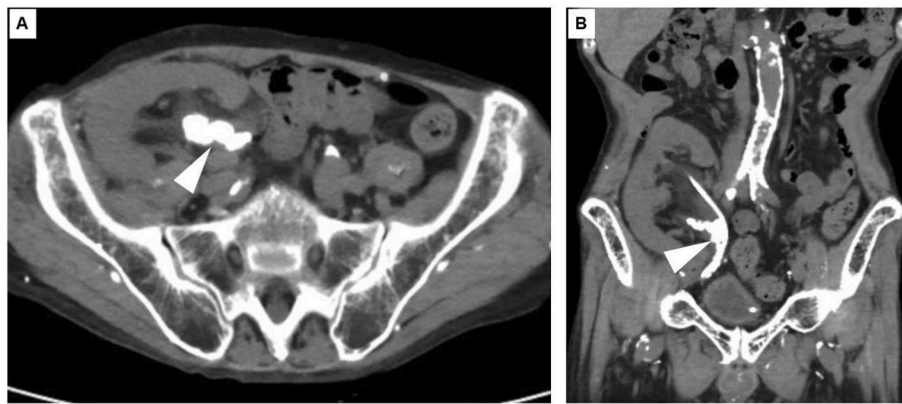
Preoperative pelvic computed tomography (CT). Pelvic CT showed multiple calculi around the indwelling ureteral stent in the transplanted kidney (white arrowhead).
